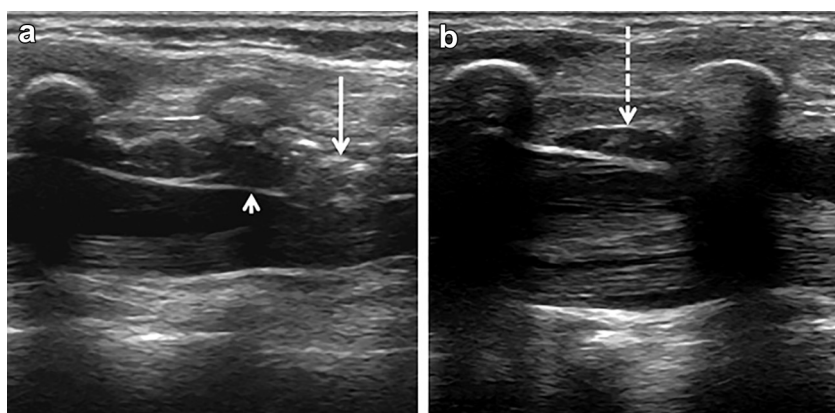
Drug movement within the epidural space observed by ultrasound in a 20-mo-old toddler (height = 79 cm, weight = 11 kg). (a) The solid arrow indicates the turbulent leading edge of the injected drug while the arrowhead indicates ventral displacement of the dura mater caused by drug movement. (b) Dotted arrow indicates the bulk movement of injected drug within the epidural space.
